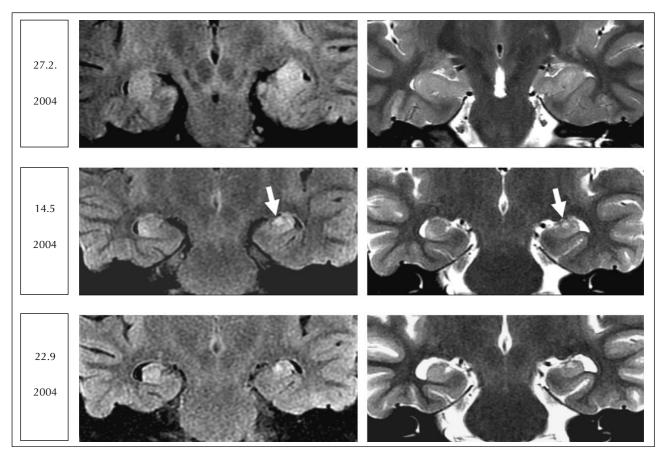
Enlarged sections of coronal FLAIR-weighted (left column) and T2-weighted (right column) images depicting the changes in the hippocampi in the first seven months after disease onset. The blow-up shows that on the left side the FLAIR/T2 signal increase is pronounced in the hippocampal endfolium (white arrows).
